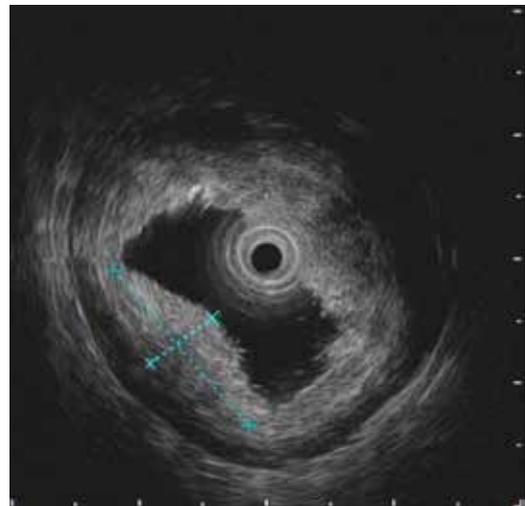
Endoscopic ultrasonography (EUS) showed middle and low echo changes and 0.6 cm thickness in the mucosal layer of the lesion with a complete submucosa.
